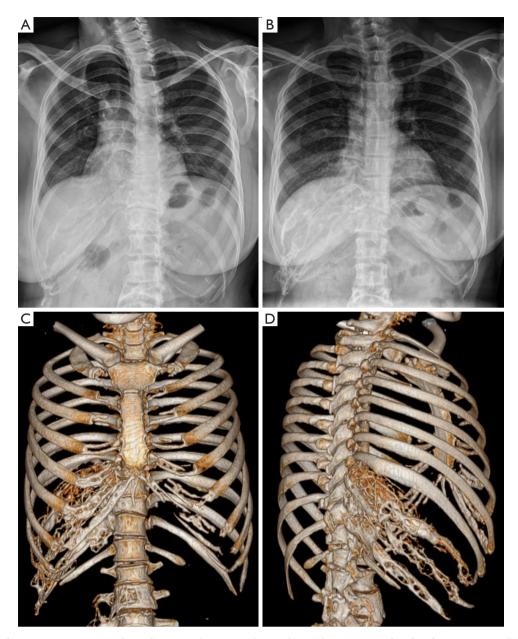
Stable disease progression is indicated on periodic review chest radiographs. (A) 3 months after first treatment. (B) 10 months after first treatment. (C,D) 18 months after first treatment.
